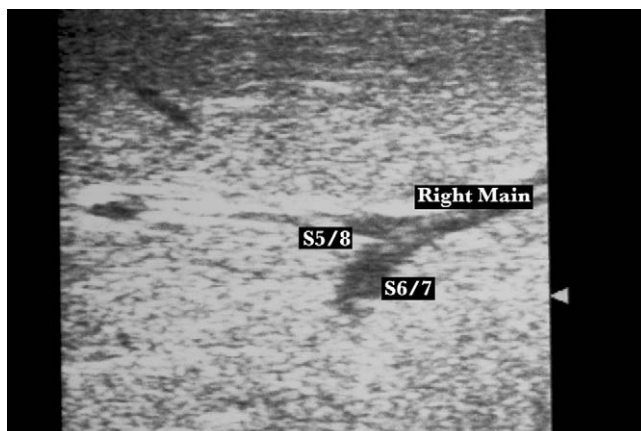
Ultrasonographic view of the right portal vein (*right main*) and its branches to the Couinaud segments 5 and 8 (*S5,8*) and 6 and 7 (*S6,7*).
